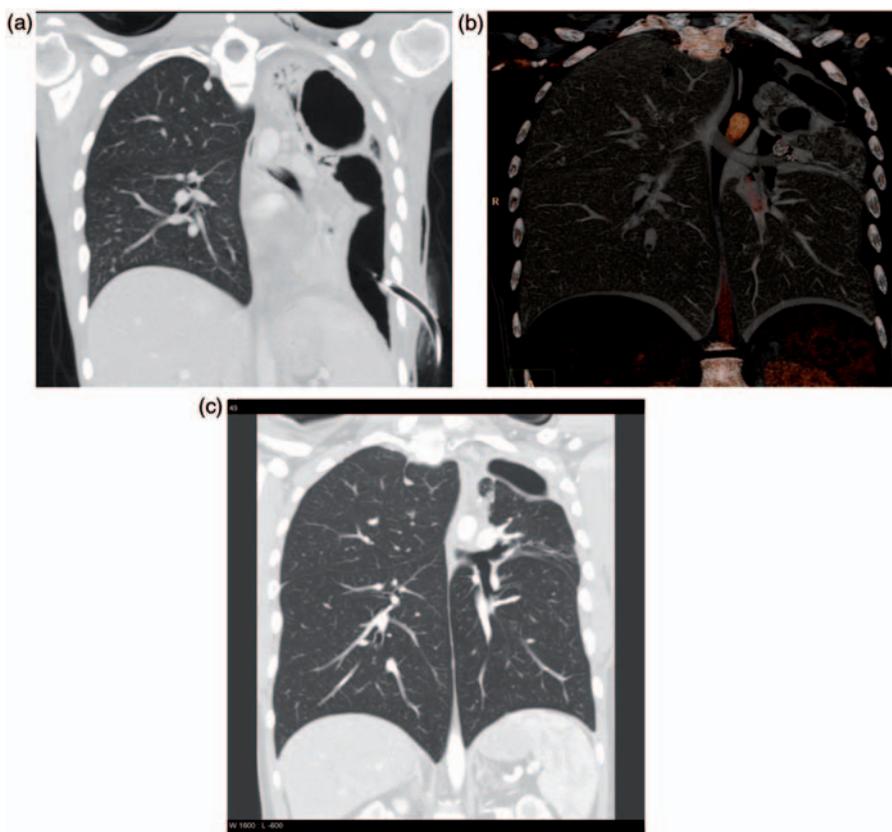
(a) Computed tomography showing necrotizing pneumonia and abscess formation in the left superior lung lobe. (b) Two one-way valves in the left upper segmental branches 2 months after endobronchial placement with a bronchoscope. (c) Computed tomography 2 years later, after the valves had been removed.
